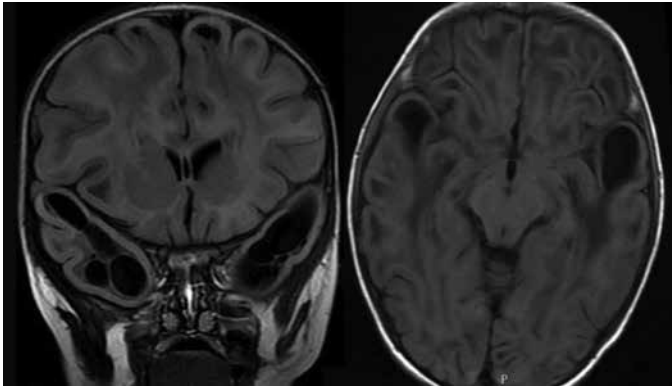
Coronal and axial T1-weighted image showing bilateral symmetrical T1 hypo-intense subcortical cysts in anterior temporal lobes and superior frontal lobes
